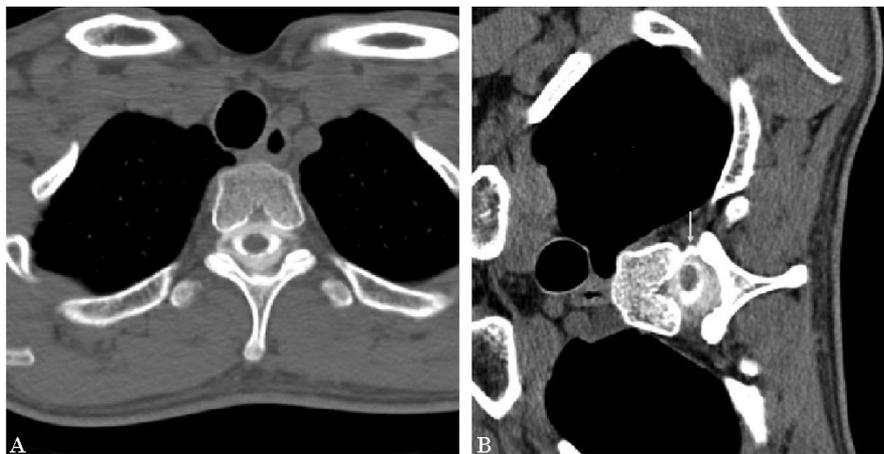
(A) Diffuse extra-arachnoid fluid collection seen on axial CT image after myelography. (B) Delayed extravasation of myelographic dye at the right T3 root with patient in the right lateral decubitus position.
